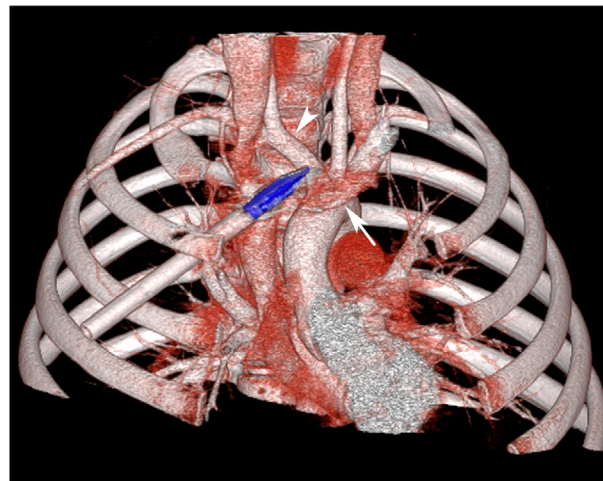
Reconstructed computed tomography coronal: Volume rendered 3-dimensional image of the chest in the coronal plane. Metallic tip of the bolt is blue. In this plane we can see how the bolt tip is in close proximity to the origin or base of the brachiocephalic artery (marked with an arrowhead) and the left innominate vein (the horizontal, faint red structure marked by the arrow)
